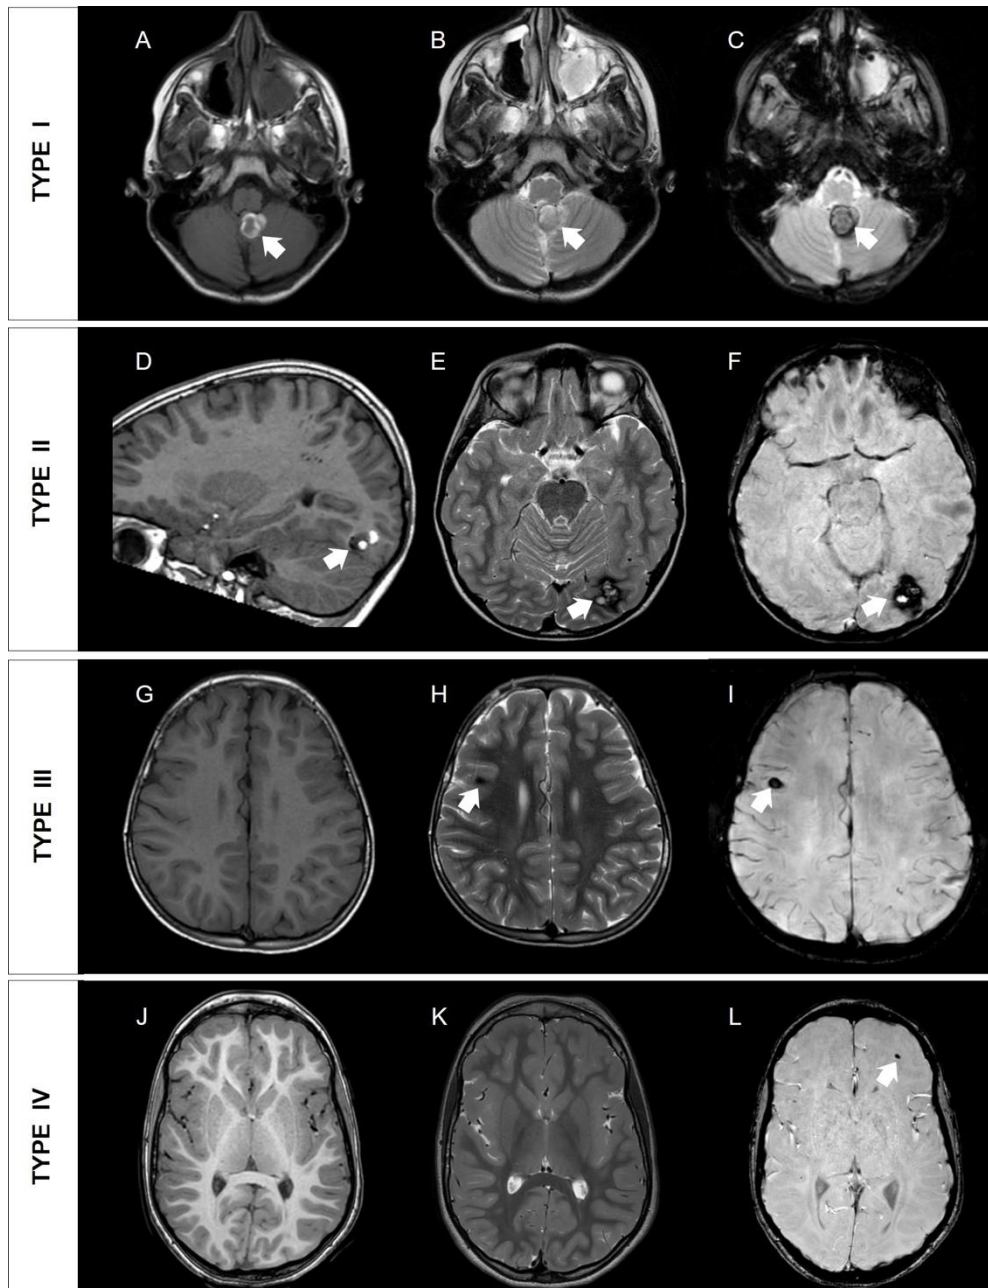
Examples of MRI classification of Zabraski types of cerebral cavernous malformations (CCM). Axial T1WI (A), T2WI (B) and magnitude SWI (C) images reveal a Zabraski type I CCM in the left cerebellar tonsil (*thick white arrows*), in keeping with subacute intralesional hemorrhage. Sagittal T1WI (D), T2WI (E) and magnitude SWI (F) images depict a Zabraski type II CCM in the left occipital region (*thick white arrows*), with the typical *popcorn-like* appearance. Axial T1WI (G), T2WI (H) and magnitude SWI (I) images show a Zabraski type III CCM in the right frontal lobe (*thick white arrows*), compatible with chronic hemorrhage. Axial T1WI (J), T2WI (K) and magnitude SWI (L) images demonstrate a Zabraski type IV CCM (also known as *dot-like* CCM) in the left frontal lobe (*thick white arrow*), with *blooming effect* on SWI and barely visible in other sequences.
